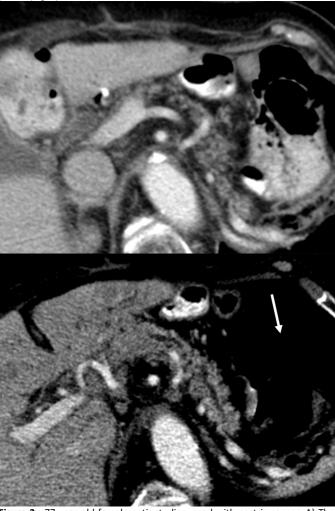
77-year old female patient, diagnosed with gastric cancer. A) The second follow-up contrast-enhanced axial abdomen CT scan: pancreatic fatty atrophy is seen. B) The third follow-up contrast-enhanced axial abdomen CT scan: pancreas parenchyma is denser compared with the former image, the pancreatic duct is dilated and ends abruptly at the neck of the pancreas (white arrow). The patient was diagnosed with pancreas cancer.
